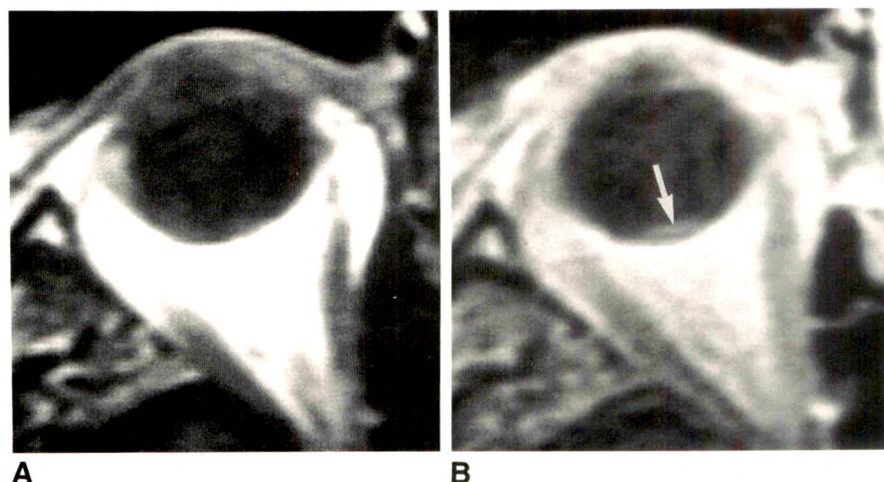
A, Axial noncontrast T1-weighted spin-echo MR image did not detect the lesion accurately.
